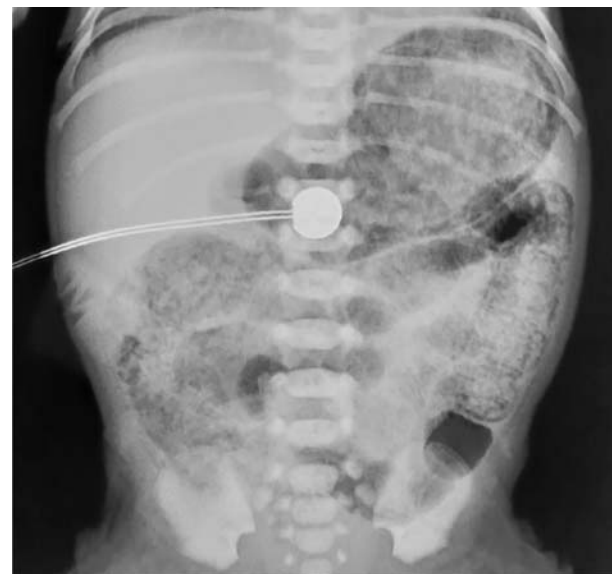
Abdominal X-ray showing dilated bowel, soap bubble appearance in the right iliac fossa, and possible pneumatosis intestinalis in left lower abdominal quadrant.
